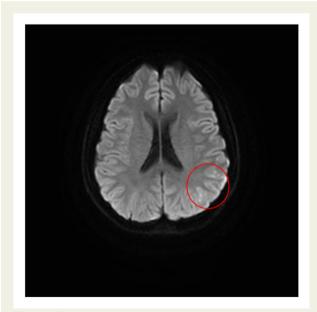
Figure I Brain magnetic resonance image (axial diffusionweighted) showing multiple high-signal-intensity lesions at the inferior territory of the left middle cerebral artery (red circle), which indicates an acute cerebral infarction in that territory.
